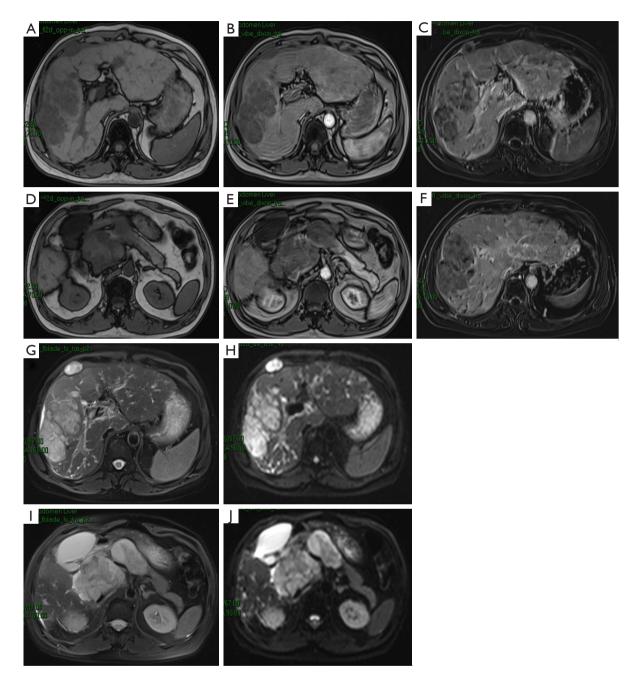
MR images before the initiation of six courses of HAIC: the largest mass size of $9.2 \text{ cm} \times 6.3 \text{ cm} \times 8.8 \text{ cm}$ in the right lobe of liver, with a massive portal lymph node lesion measuring $5.6 \text{ cm} \times 7.2 \text{ cm}$ in size. (A,D) Transverse T1-weighted imaging. (B,E) Contrast-enhanced dynamic T1-weighted arterial phase and (C,F) delayed phase imaging. (G,I) Transverse T2-weighted and (H,J) transverse diffusion-weighted imaging. MR, magnetic resonance; HAIC, hepatic arterial infusion chemotherapy.
